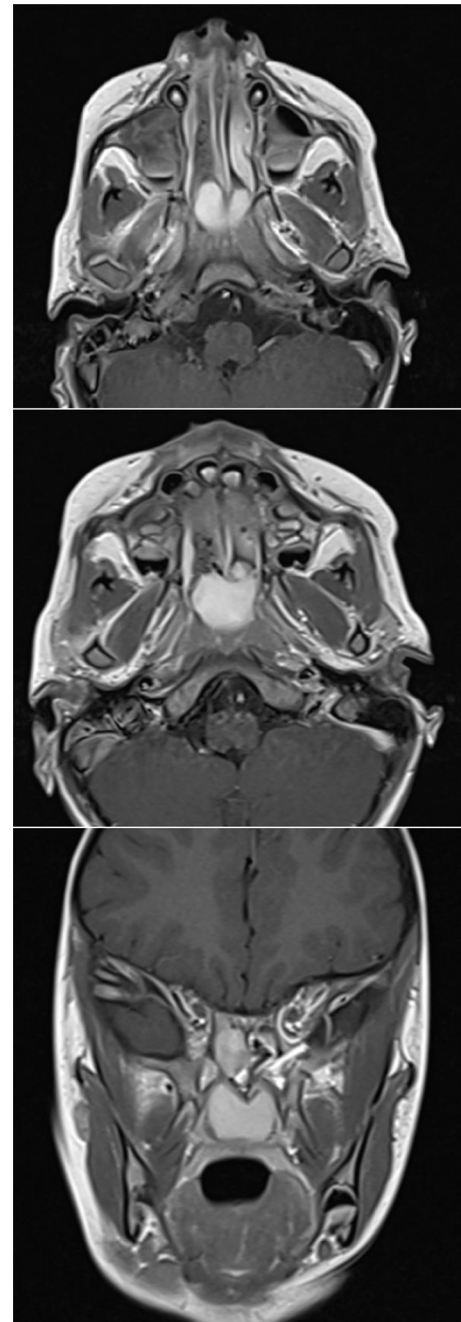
Contrast-enhanced MRI. Embossing of the mass in nostrils and nasopharynx, in contrasted T1 sequences, is evidenced. The mass extends from the right to the left nostril through the coanal orifice.
